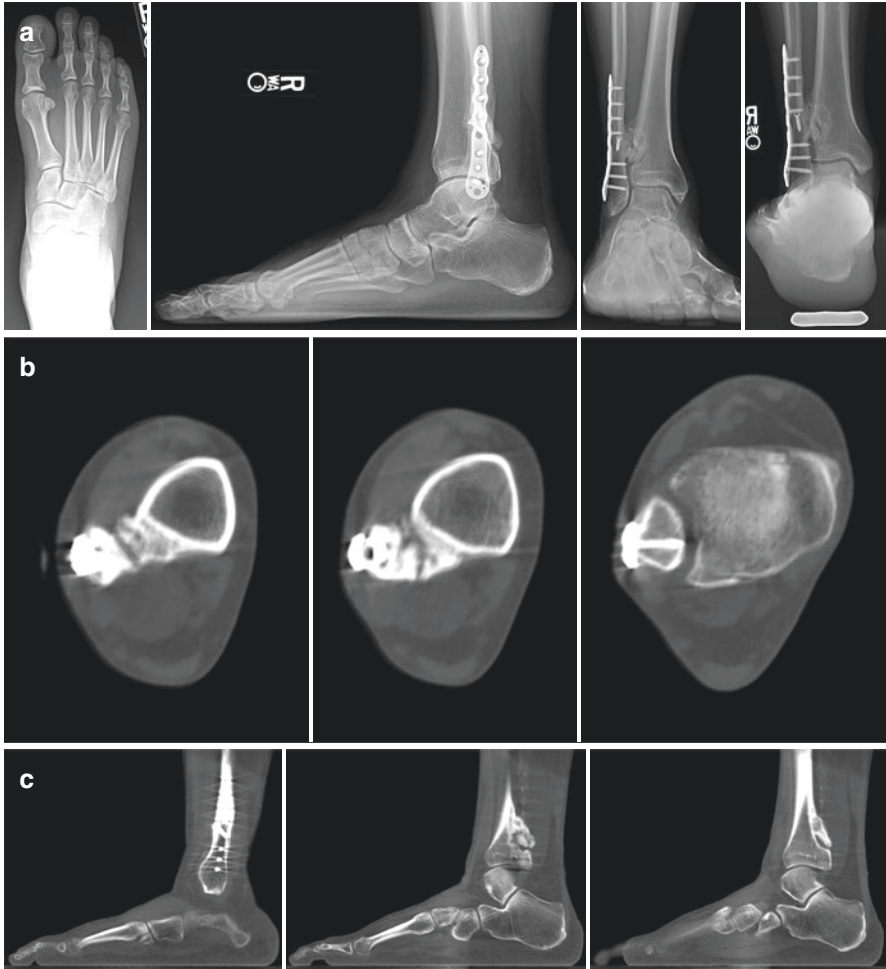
Demonstrates usage of WBCT in a 35-year-old male with a missed syndesmosis injury. Three years ago, the patient underwent an open reduction and internal fixation of a distal fibula fracture in an outside facility. However, at the time of the surgery, the concomitant syndesmosis injury was not recognized. (a) Weight bearing radiographs (from left to right: anteroposterior and lateral views of the foot, mortise view of the ankle, and hindfoot alignment view) demonstrate complete union of the distal fibula fracture; however, they also demonstrate substantial degeneration of the distal tibiofibular joint a significant amount of heterotopic ossifications. (b) Axial, (c) sagittal, and (d) coronal WBCT demonstrate severe degeneration of the distal tibiofibular joint with subluxation of the fibula within the incisura. A deep debridement of the heterotopic ossification using a transfibular approach was performed. Additionally, a realigning arthrodesis of the distal tibiofibular joint with use of a proximal tibia bone graft (cancellous bone) was installed. (e) At the 4-month postoperative follow-up, weight bearing radiographs (from left to right: anteroposterior and lateral views of the foot, mortise view of the ankle, and hindfoot alignment view) were acquired and demonstrate progressive union of the distal tibiofibular arthrodesis and appropriate hardware positioning. However, conventional radiographs do not allow a reliable assessment of union degree or fibular alignment within the incisura. Due to this shortcoming, a postoperative (f) axial, (g) sagittal, and (h) coronal WBCT was acquired and demonstrates progressive, near complete union of the distal tibiofibular arthrodesis and anatomic alignment of the distal fibula in all three planes
